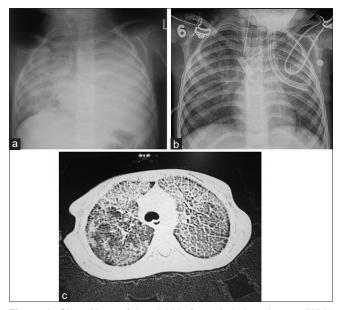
Chest X-ray of the child before whole lung lavage (WLL) (a), after WLL (b), and highresolution computerized tomography chest image before WLL (c)
